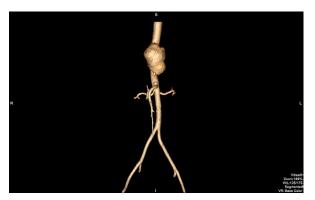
Computed tomographic scan (3-dimensional reconstruction) shows the distinctive shape of the saccular aneurysm, which incorporates the celiac axis in its distal aspect.
